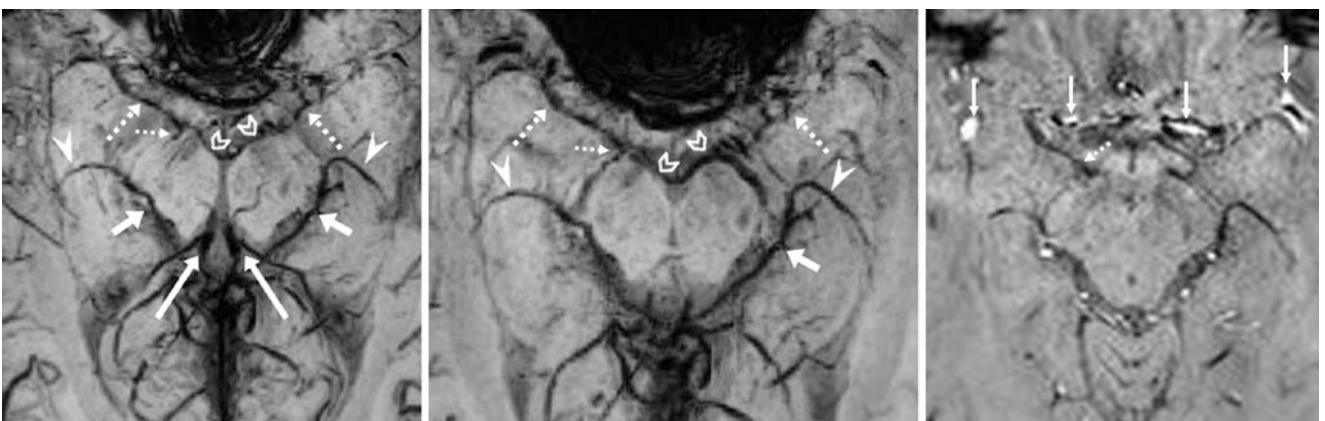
In this 15-year-old, a 3 T SWI MRI at 21 mm thickness (*left*) shows asymmetric basal drainage, with a dominant left BVR (*short arrows*) and a dominant right deep MCV (*dotted arrows*). Note interpeduncular veins (*chevrons*), internal cerebral veins (ICVs, *long arrows*), IVVs (*arrowheads*), and a right uncal vein (*thin dotted arrow*).
